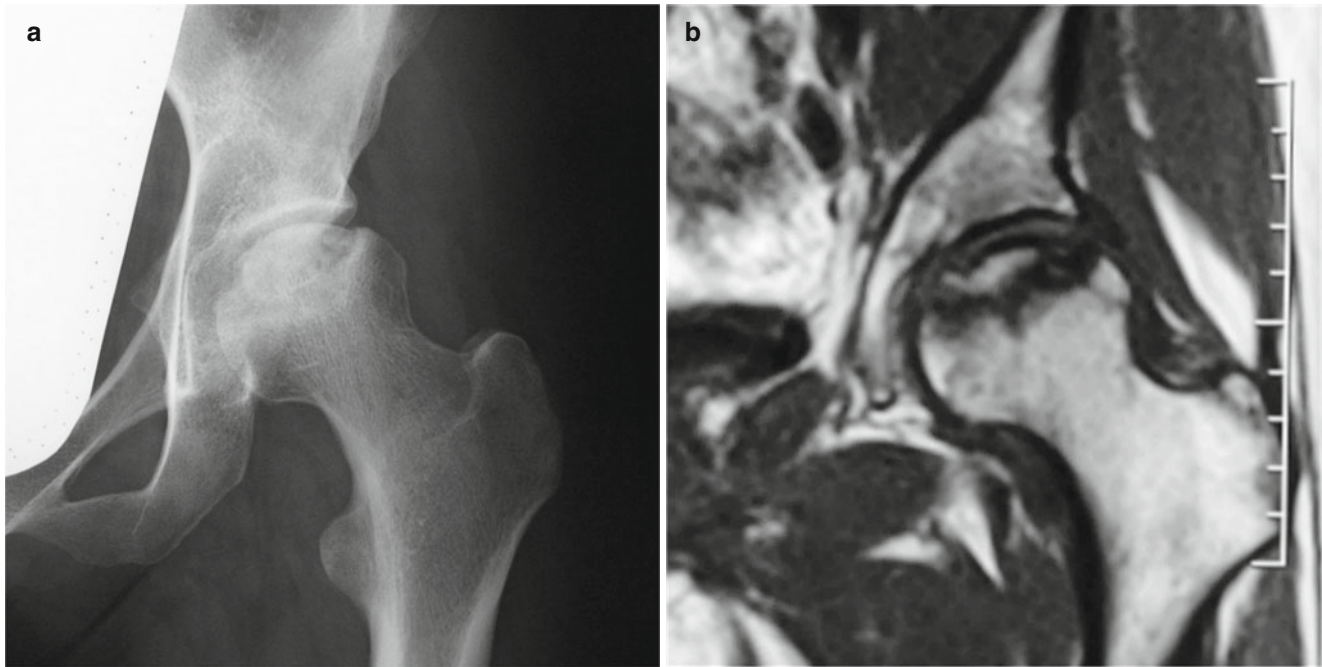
A 27-year-old woman having high dose of corticosteroids due to treatment of sclerotic lupus erythematosus. (a) Preoperative anteroposterior radiograph of her left hip showed large collapsed
